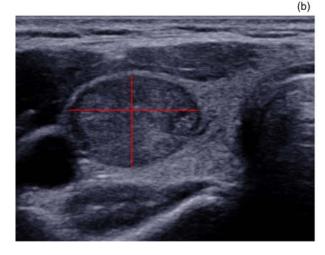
Measurement of the anteroposterior-to-transverse ratio. The ratio was calculated on the transverse ultrasound image of the thyroid nodules, as follows: anteroposterior-to-transverse ratio = (vertical height of nodule) / (horizontal width of nodule). (a) The nodule was papillary carcinoma, and its anteroposterior-to-transverse ratio was 1.42; (b) The nodule was adenoma, and its anteroposterior-to-transverse ratio was 0.71. The red lines reflect the vertical height and horizontal width of the nodules.
